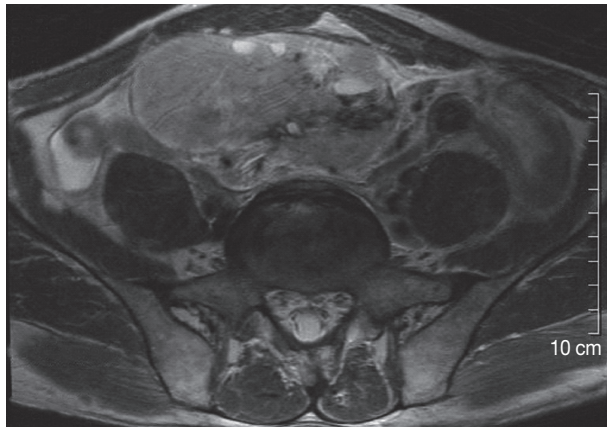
A T2-weighted magnetic resonance imaging shows a heterogeneous tumor involving the lower peritoneal cavity.
